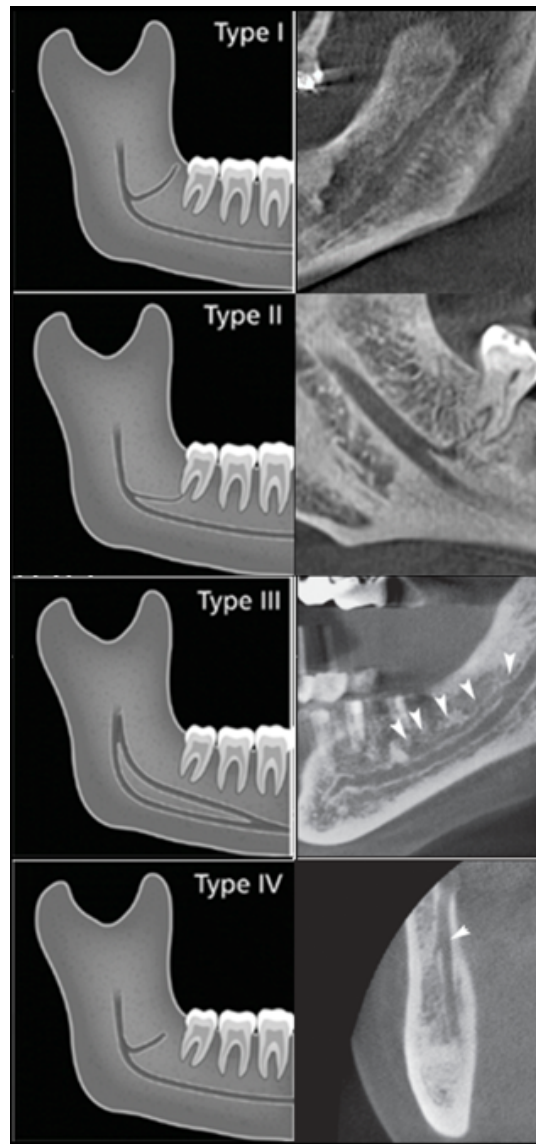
CBCT examples of the four types of bifid canals according to Naitoh 2009.
